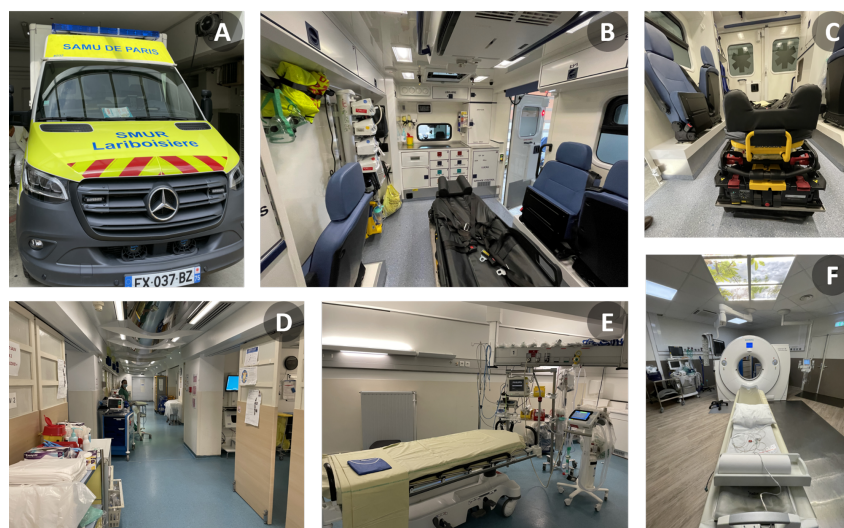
Emergency installations. A: Movil Emergency Care Unit (Ambulance); (B) A interior; (C) A gurney; (D) emergency department; (E) emergency room; (F) CT Scanner².
